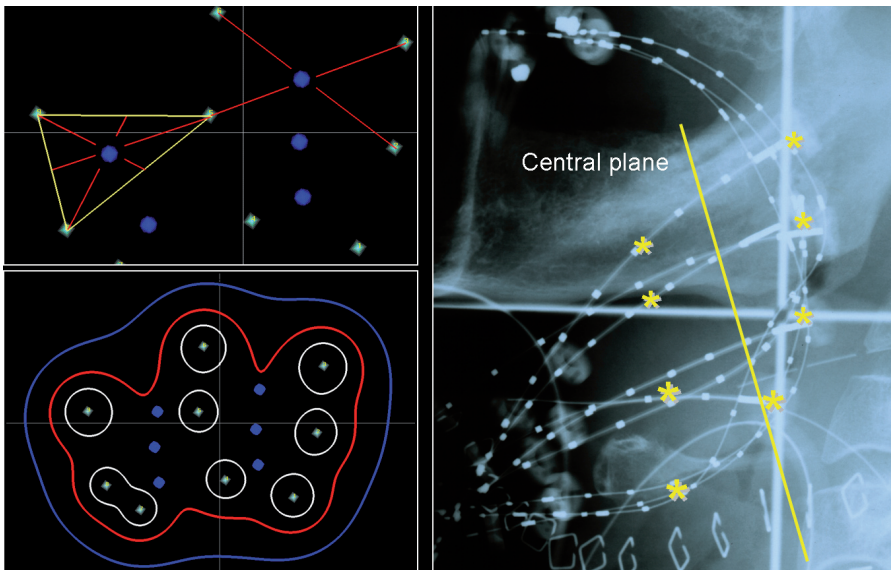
Patient with BOT implant. Sagittal view X-ray film of catheters with dummy sources in situ (right panel). Yellow line depicts central calculation plane. Also shown is cross section of tumor in central plane (left panel). Blue dots are basal dose points (“centers of gravity”). White dots represent “sources”. Dose is prescribed to 85% of mean central dose (= average of doses calculated in centers of gravity of all triangles).
